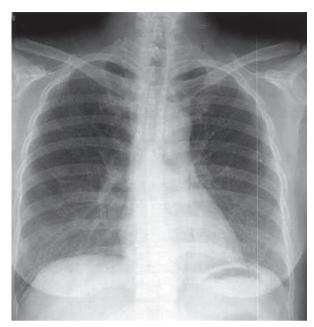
Chest radiograph at week 4, showing dramatic improvement.
